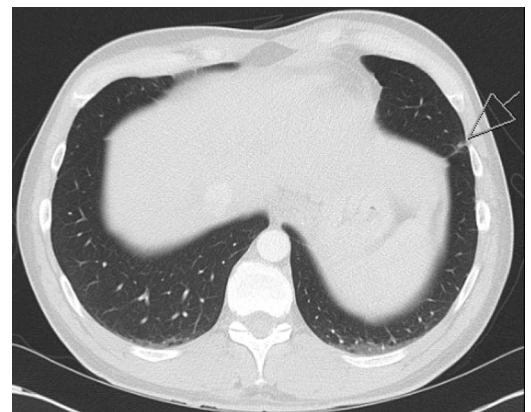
Thorax CT scan 29 September: regredient mass lesion in the lingula.
